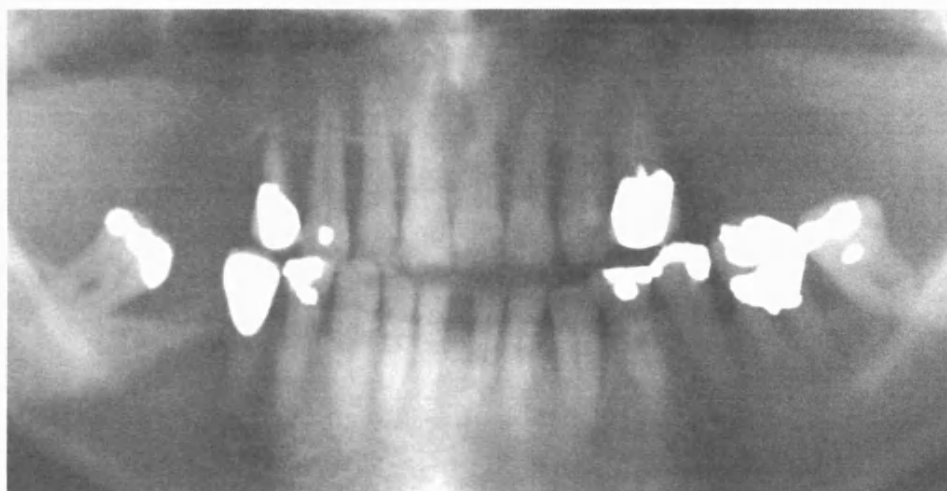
Orthopantomograph of the 50-year old father of the patient shown in figure 8.3 (the radiograph was taken when the patient was 40 years old). A generalised pattern of alveolar bone loss is present both in the maxilla and in the mandible.
